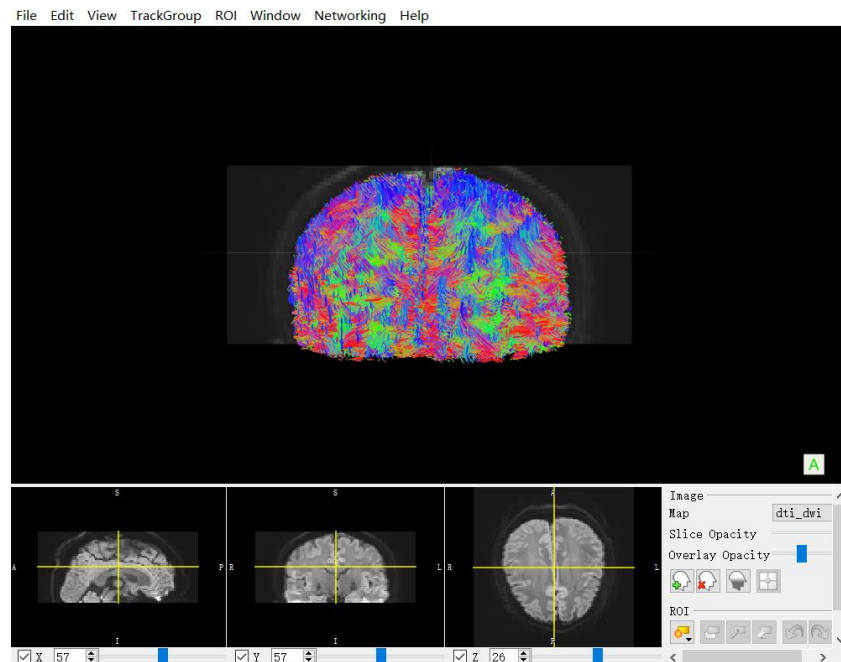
Fiber tracts image and DWI image showed in Trackvis.
